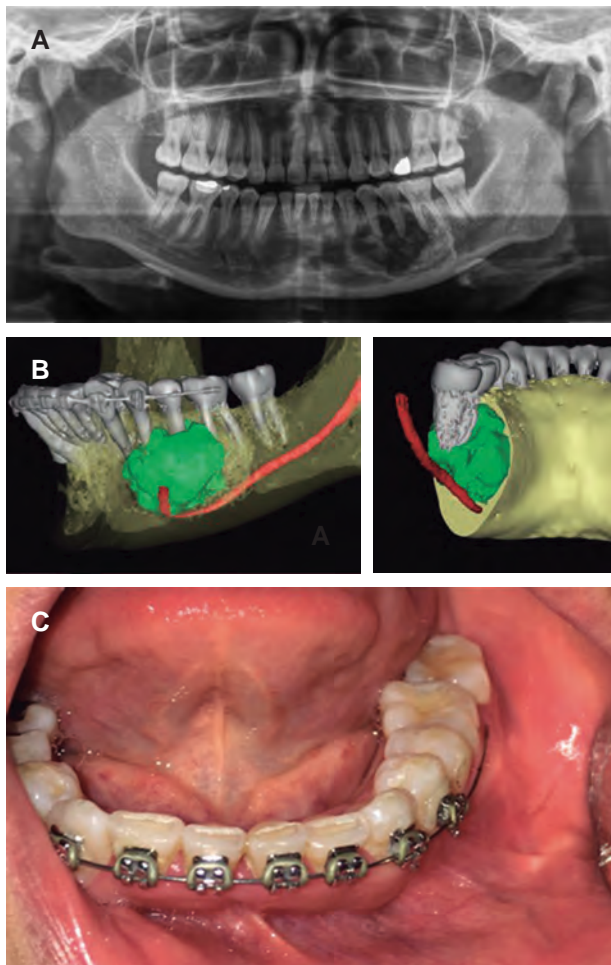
Clinical and imagenologic findings. A) Orthopantomography showing osteolytic area in the left mandibular body. B) Volumetric reconstruction of the same lesion. C) Clinical image, not showing changes in the oral mucosa, or apparent increase in volume in the left mandibular body.
